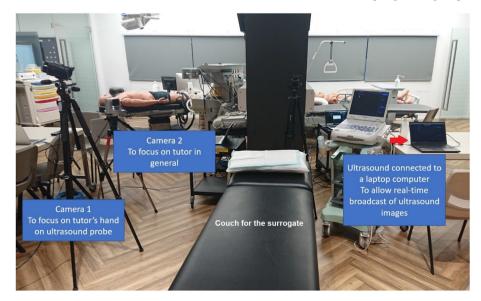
Setup of the online ultrasound teaching (OUT) session.
